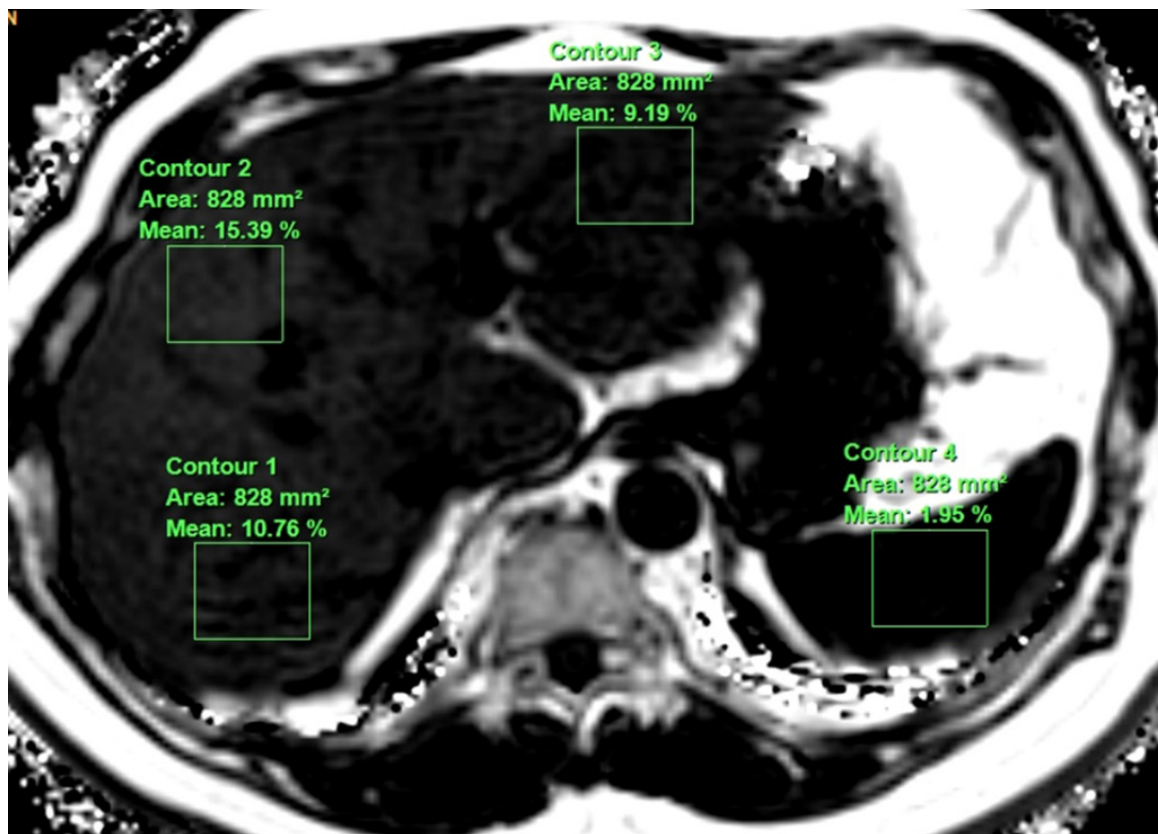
Fast-spoiled gradient echo MR image of fat mapping image, showing measurement area including the posterior segment of the right hepatic lobe (contour 1), the anterior segment of the right hepatic lobe (contour 2), the left hepatic lobe (contour 3), and the spleen (contour 4).
